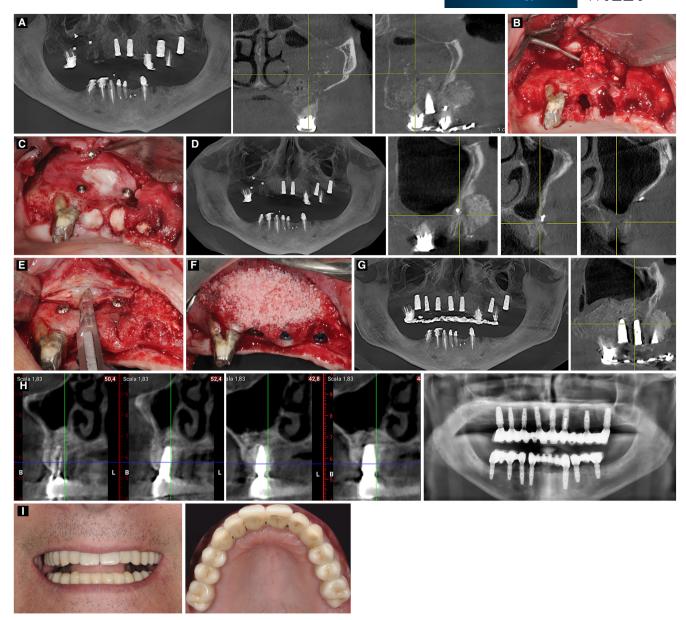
A, Patient referred to our institution to address a persistent infection at 3 weeks post-sinus elevation. A second regimen of antibiotics was immediately administrated (500 mg levofloxacin twice a day for 7 days) without resolution of the symptoms. Cone beam computed tomography examination revealed a sinus radiopacity with graft particles that seem dispersed into the sinus cavity. Detailed clinical procedure follows. B, A full thickness flap was reflected; the implant and hopeless tooth (strategically kept to anchor a metal-reinforced prosthesis) were removed along with the graft particulate. C, After complete graft removal, a collagen membrane was fixed to the buccal bony wall followed by primary flap closure. D, The 2 months postoperative cone beam computed tomography delineates normal sinus mucous membrane anatomy but identifies a fenestration at the level of the antrostomy. E, At 2 months postoperatively, a split-thickness flap is performed. F, A second sinus elevation is performed, and three additional implants are positioned. G, Immediate postoperative cone beam computed tomography shows a cemented provisional prosthesis supported by three natural abutments that will be replaced after graft consolidation and implant osseointegration. H, The 5-year follow-up. Clinical photographs of the final prosthesis. I, The 5-year follow-up. Panorex of the final prosthesis
